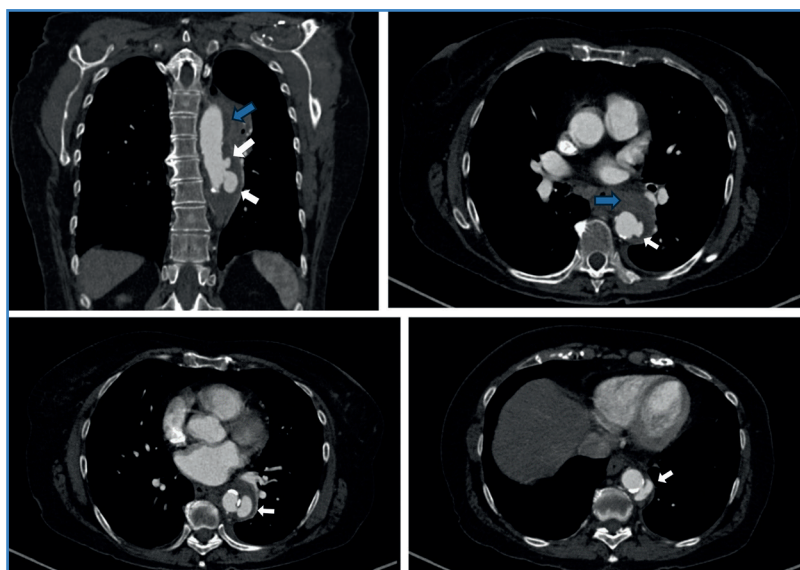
Preoperative angio-CT showing a periaortic collection in relation to the left upper lung lobe (blue arrow) and images consistent with the 3 pseudoaneurysms described in the descending thoracic aorta (white arrows).
